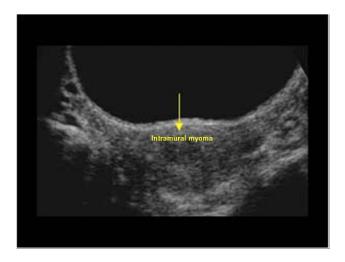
Transvaginal ultrasonography of intramural myoma.
